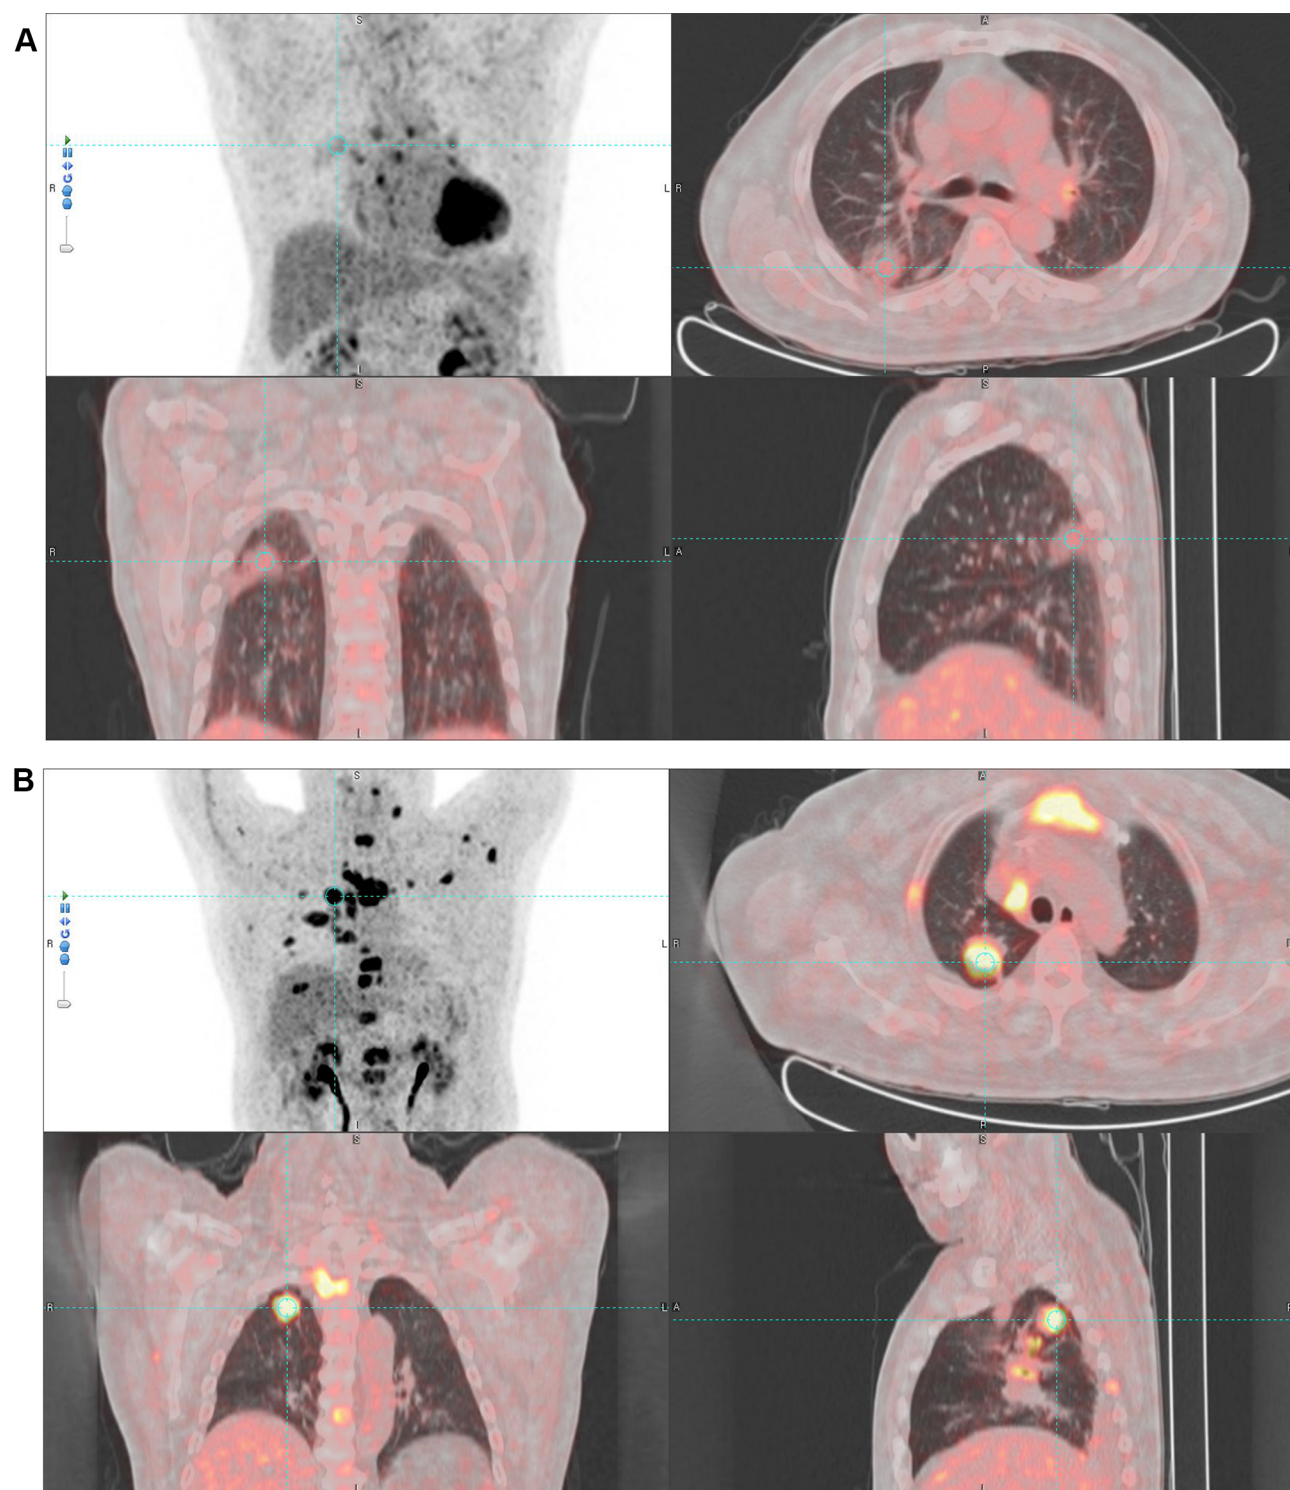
Representative examples of PET/CT images of *EGFR*-mutated patients with different metabolic parameters showing different clinical outcomes. (A) A case of a 75-year-old man having a primary tumor in the right upper lobe. $MTV_{1.5}$ is 8.6 and $TLG_{1.5}$ is 14.5. His PFS and OS are 12.6 and 18.7 months, respectively. (B) A case of a 76-year-old man having a primary tumor in the right upper lobe. $MTV_{1.5}$ is 22.7 and $TLG_{1.5}$ is 71.8. His PFS and OS are 5.4 months and 9.7 months, respectively.
